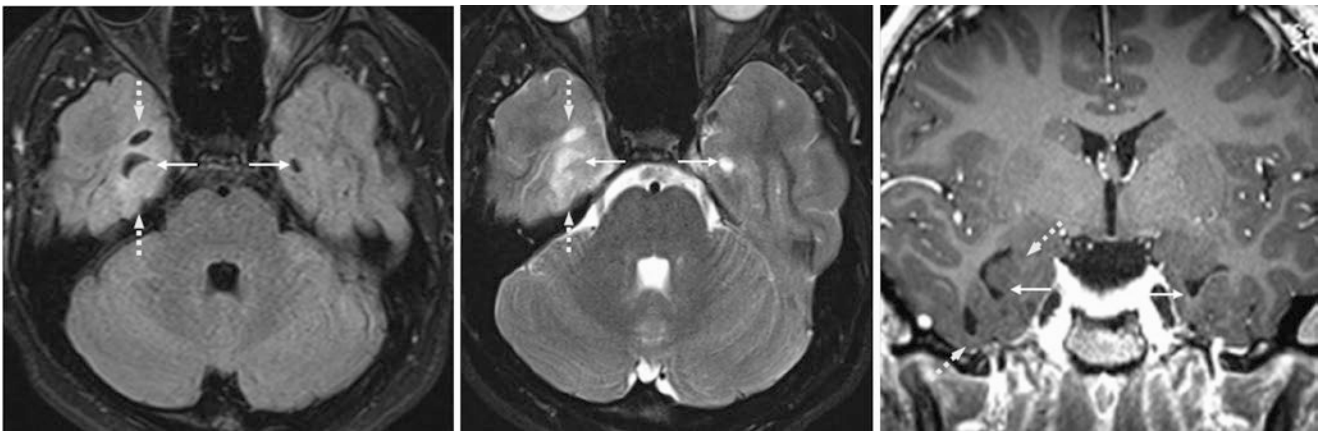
Comparison case of presumed low-grade glioma. A 25 year old with seizures had a right medial temporal lobe mass on a 1.5 T MRI with axial T2WI (*left*) and FLAIR (*left middle*). The mass did not enhance on postcontrast T1WI (*right middle*) and was not biopsied but
